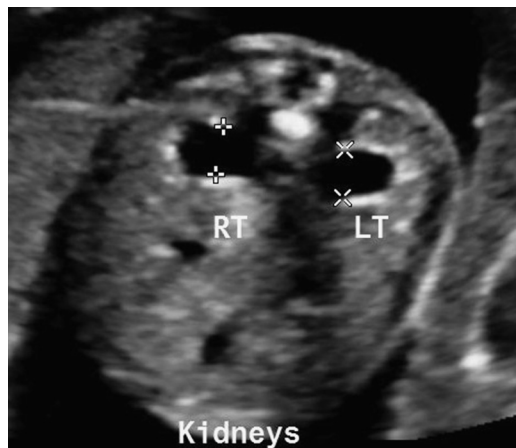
Prenatal diagnosis of SERP. 20-week prenatal ultrasound depicting a transverse image of the fetal kidneys. APD measurements of the renal pelvis are 6.2 mm on the right (RT) and 6.1 mm on the left (LT). Postnatal ultrasound revealed SFU grade 1 on the right and SFU grade 2 on the left.
